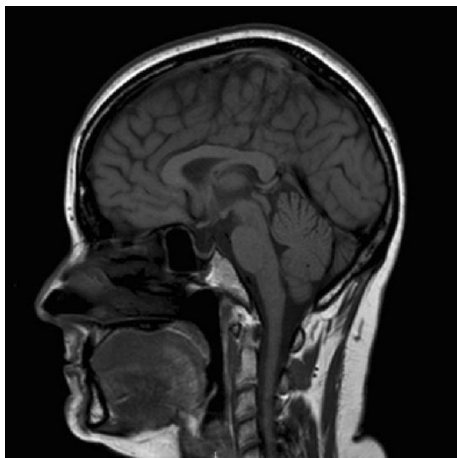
MR T1-weighted sagittal image showing total empty sella, with the flattening of the hypophyseal tissue at the bottom of the sella turcica
